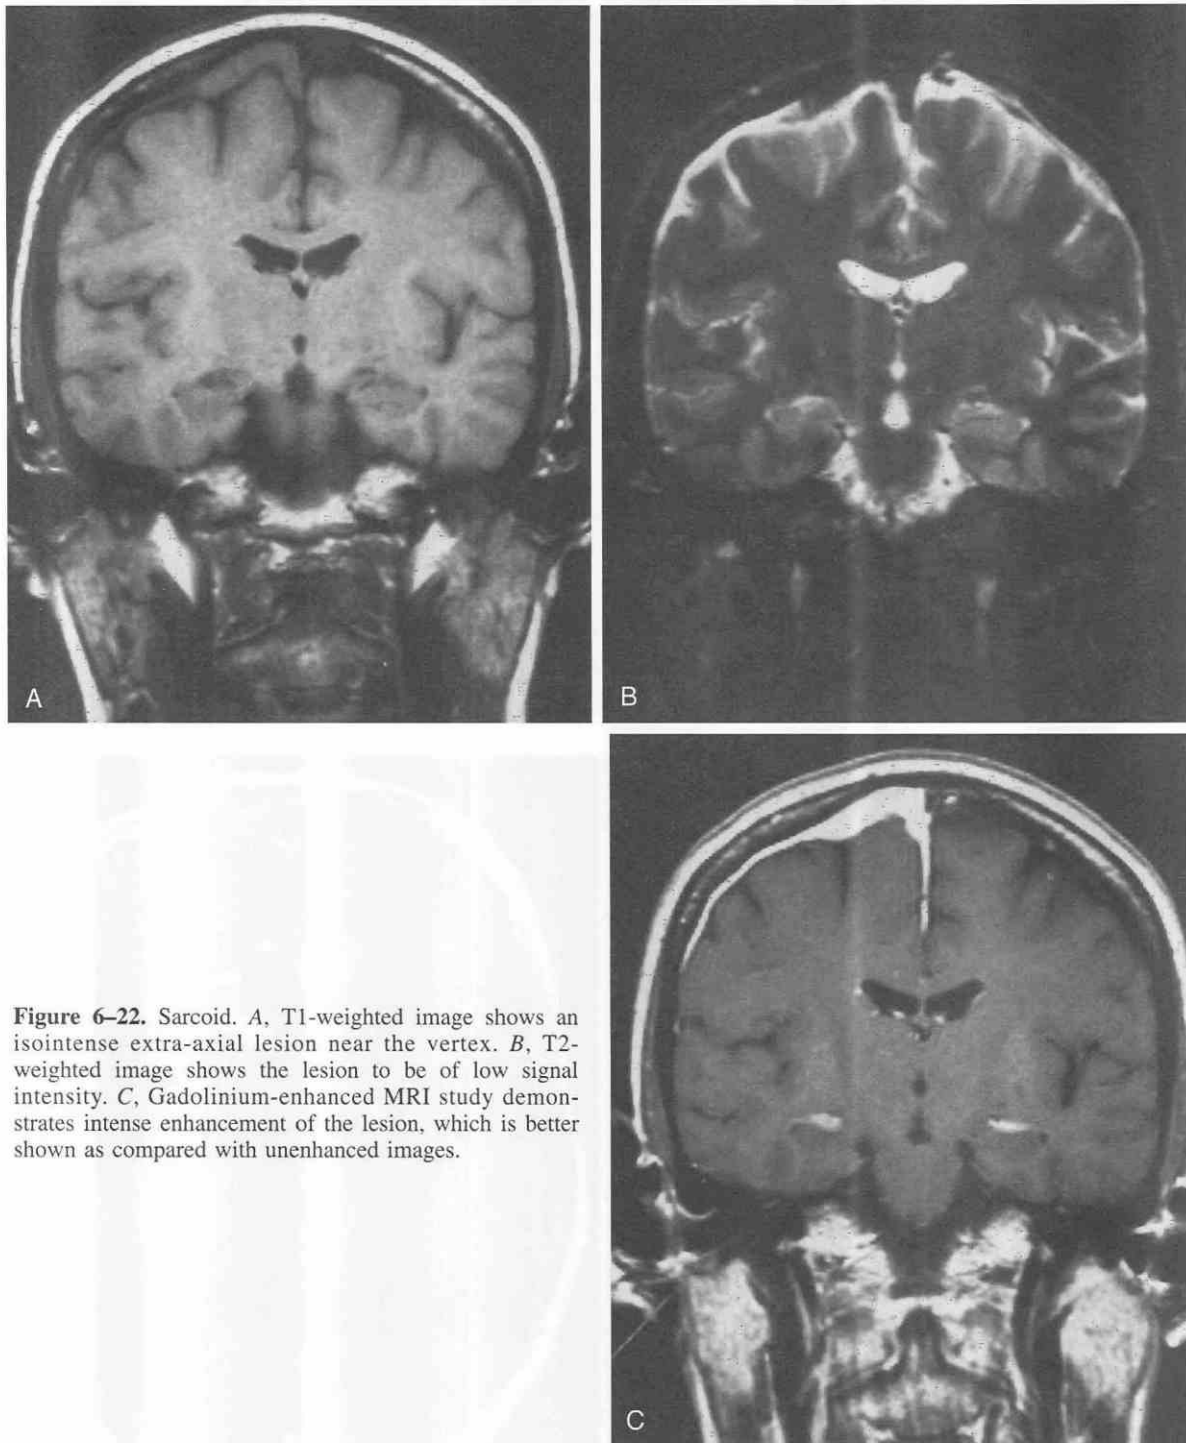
Sarcoid. A, T1-weighted image shows an isointense extra-axial lesion near the vertex. B, T2-weighted image shows the lesion to be of low signal intensity. C, Gadolinium-enhanced MRI study demonstrates intense enhancement of the lesion, which is better shown as compared with unenhanced images.
